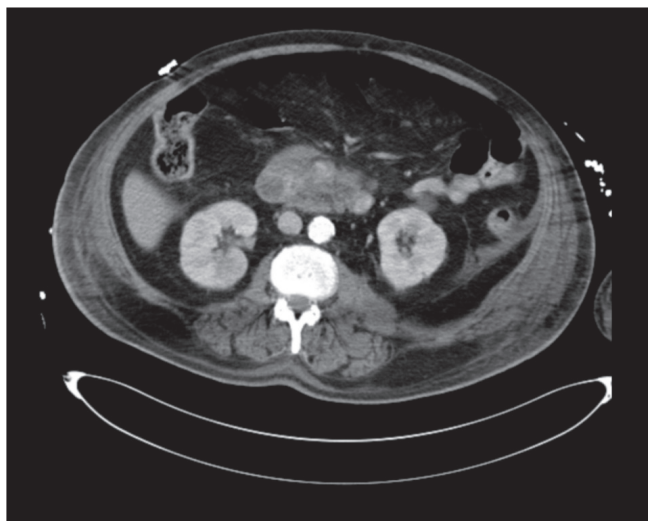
CT image in which part of an inflammatory periduodenum process is observed.
